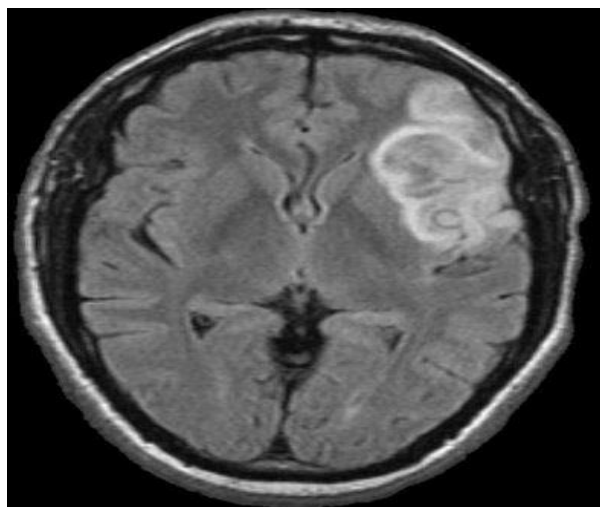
MRI brain axial T2 (Ronald L.Eisenberg Nancy M. Johnson ,Comprehensive Radiographic Pathology)
